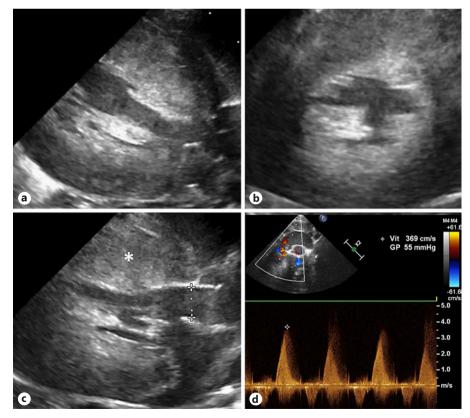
Postnatal echocardiography. Long axis view of the heart (a) and parasternal minor axis view (b) showing severe concentric left ventricular hypertrophy. Parasternal long-axis view showing left ventricular outflow tract and a thickened ventricular septum* (c). Pulsed Doppler flow of the ascending aorta showing left ventricular obstruction with peak systolic gradient of 55 mm Hg (d).
